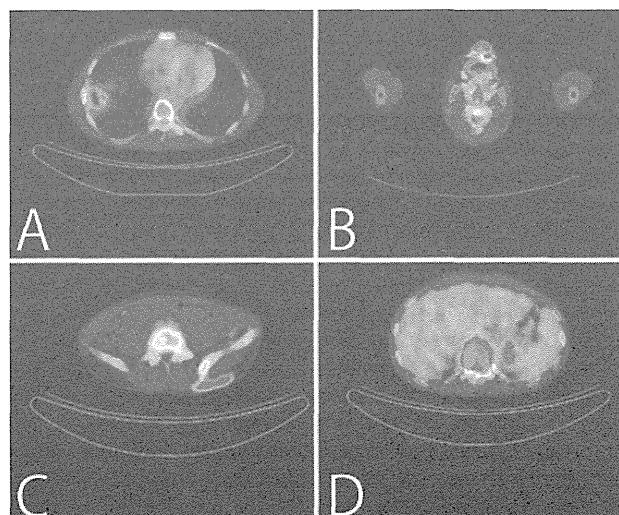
PET-CT scans showing pathological FDG uptake in the lung (A), upper jaw (B), left hip (C), and T-11 vertebral body (D).
